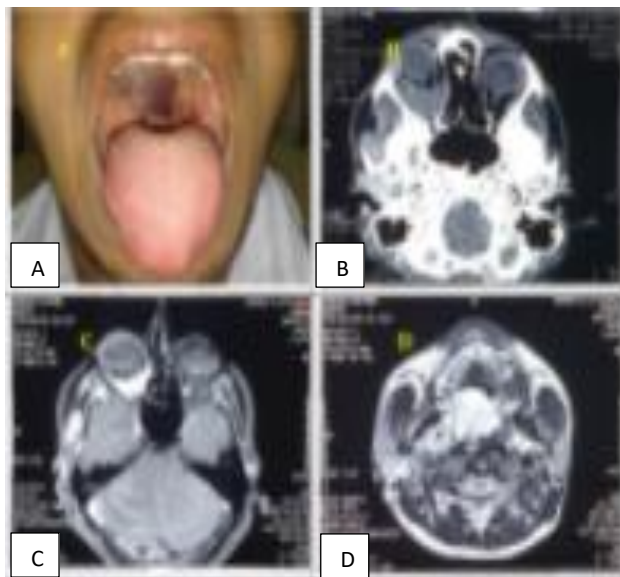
(A-D): Bluish vascular mass in the soft palate going into the right tonsillar fossa and uvula; CECT scan through orbit showing ill-marginated soft tissue lesion in the right orbit; gadolinium enhanced MRI showing enhancing soft tissue lesion in the right orbit; gadolinium enhanced MRI of enhancing soft tissue mass lesion in the right masseteric space and infratemporal fossa.
